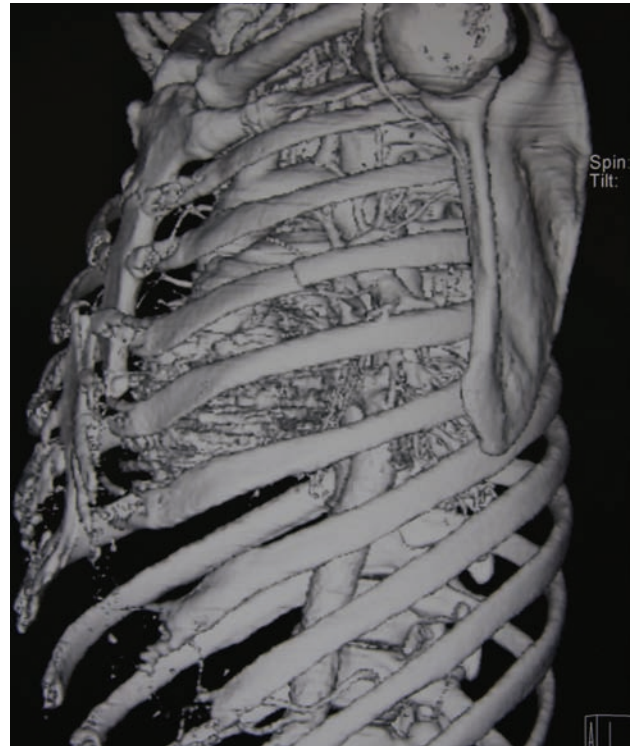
Computed tomography scan of the patient in case 2.
